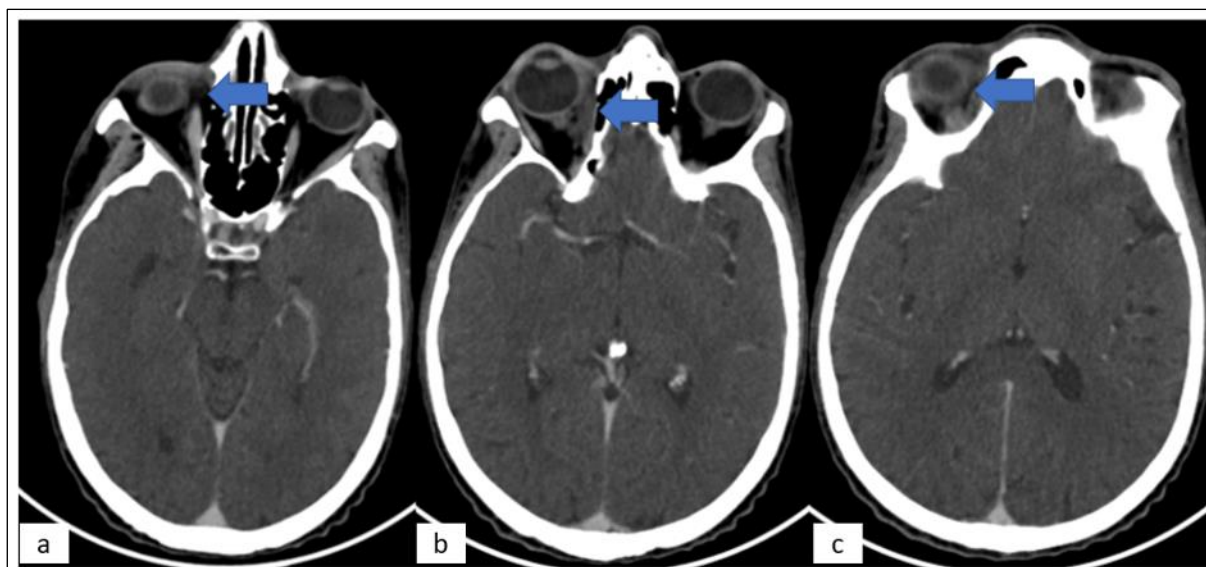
Control CT shows near-complete regression of the right intraorbital and intraconal soft tissue process centered on the superonasal quadrant, replaced by hypodense intraconal infiltration at this level (arrows a, b and c).
